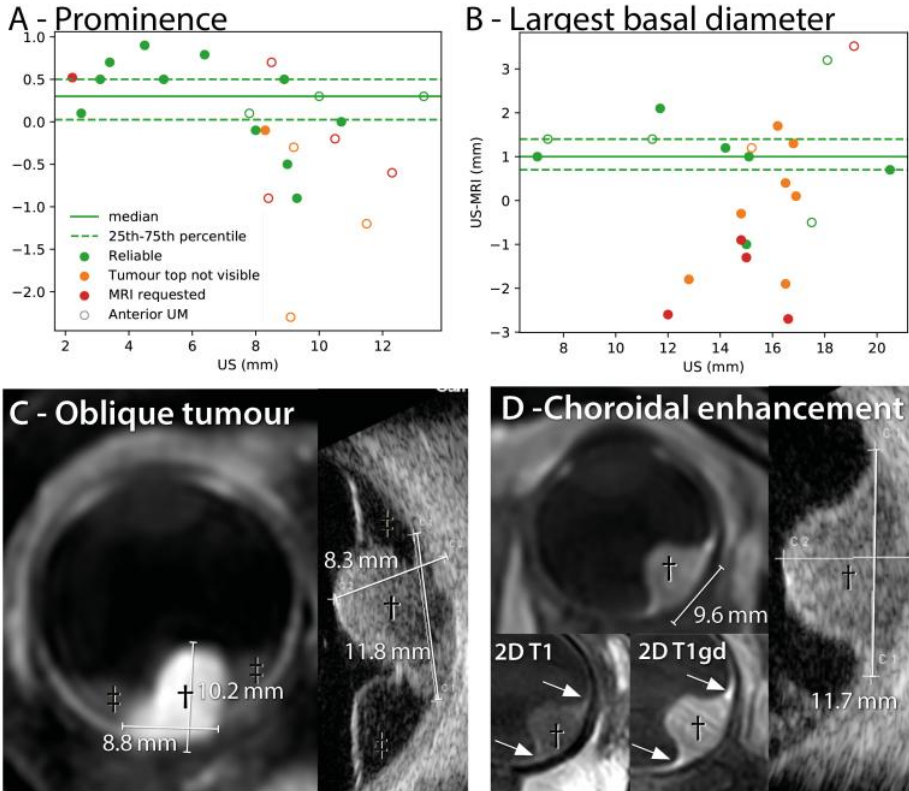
Comparison between ultrasound and MRI measurements of the tumor geometry (A) For 5 patients (red), an MRI was requested due to doubts on the accuracy of the ultrasound measurements. Additionally, 7 ultrasound measurements were scored as potentially inaccurate (orange), as they did not show the complete tumor in the FOV. Notably, for 10 of these 12 patients the tumor was located anteriorly (open markers). Overall, the largest differences were observed in anterior UM. (B) For the patients with a reliable ultrasound measurement, an average absolute difference between both techniques of 1.2 mm for the largest and 1.6 mm for the second basal diameter was found. Overall, the largest differences were observed in unreliable ultrasound measurements. (C) Prominence measurements for oblique oriented tumors are not well defined and can differ between observers on both ultrasound and MRI. (D) On MRI, choroidal enhancement was not included in the basal diameter measurements. On ultrasound however, this appears to be included.
